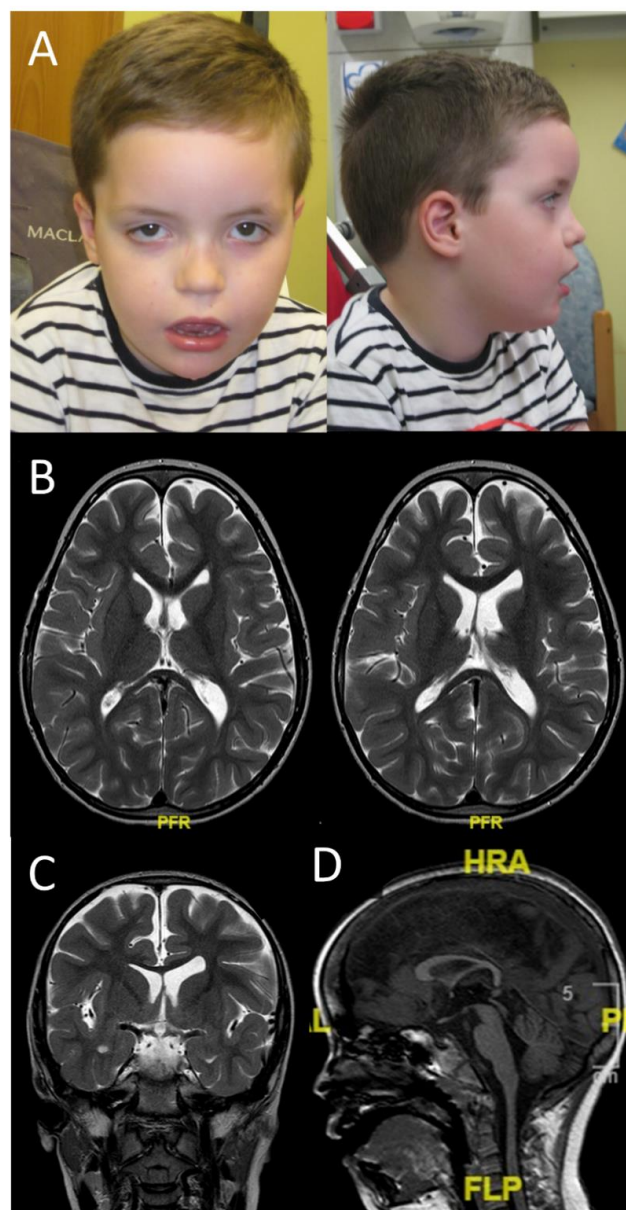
Photographs and MRIs for Patient 1 obtained with parental consent. A) Facial photographs showing frontal bossing, laterally sparse eyebrows, mild hypertelorism, proptosis, depressed nasal bridge, long philtrum, thin tented upper lip, everted lower lip and drooling. B) Axial T2W MRI images showing oversimplification of gyral pattern of frontal cortex with dysgyric cingulate cortex anteriorly, asymmetry of lateral ventricles, and normal basal ganglia. C) Coronal T2W MRI image showing oversimplification of gyral pattern of anterior cortex with dysgyric cingulate cortex anteriorly, asymmetry of lateral ventricles, and normal basal ganglia. There is no evidence of polymicrogyria. D) The midline sagittal T1W image shows thin corpus callosum and a degree of inferior vermis hypoplasia. Clinical images are not available for Patients 2-5.
